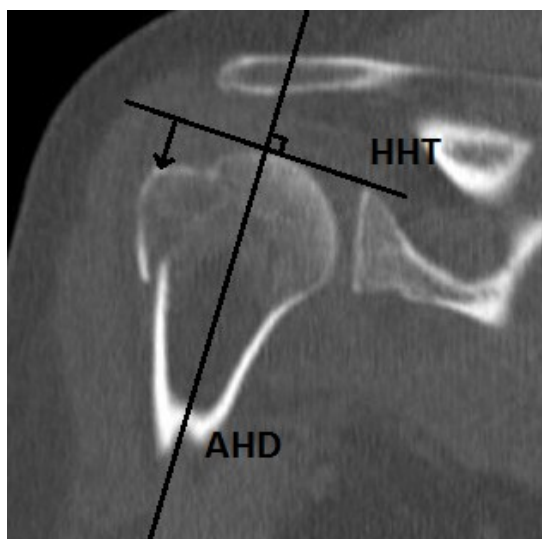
Measurement of Superior/Inferior GT Displacement relative to HHT on Coronal CT Reconstruction
